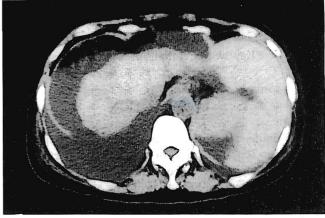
Abdominal CT showed a severely atrophic liver, ascites, pleural effusion and splenomegaly (72nd days after onset of the disease).
